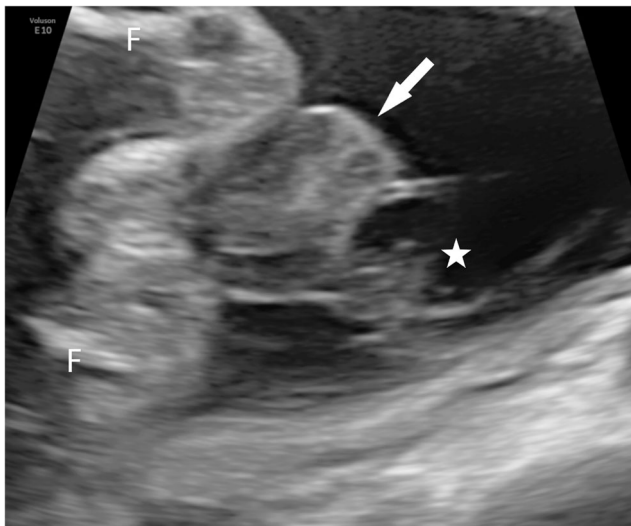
A transverse image from a fetal ultrasound at 28 weeks' gestation at the level of the umbilical insertion. The bladder is no longer seen in the fetal pelvis. A mass (*arrow*) is present outside the abdominal wall and adjacent to the umbilical cord and represents an everted and herniated bladder. Note that the umbilical cord cyst (*star*) is significantly smaller. *F* femur
